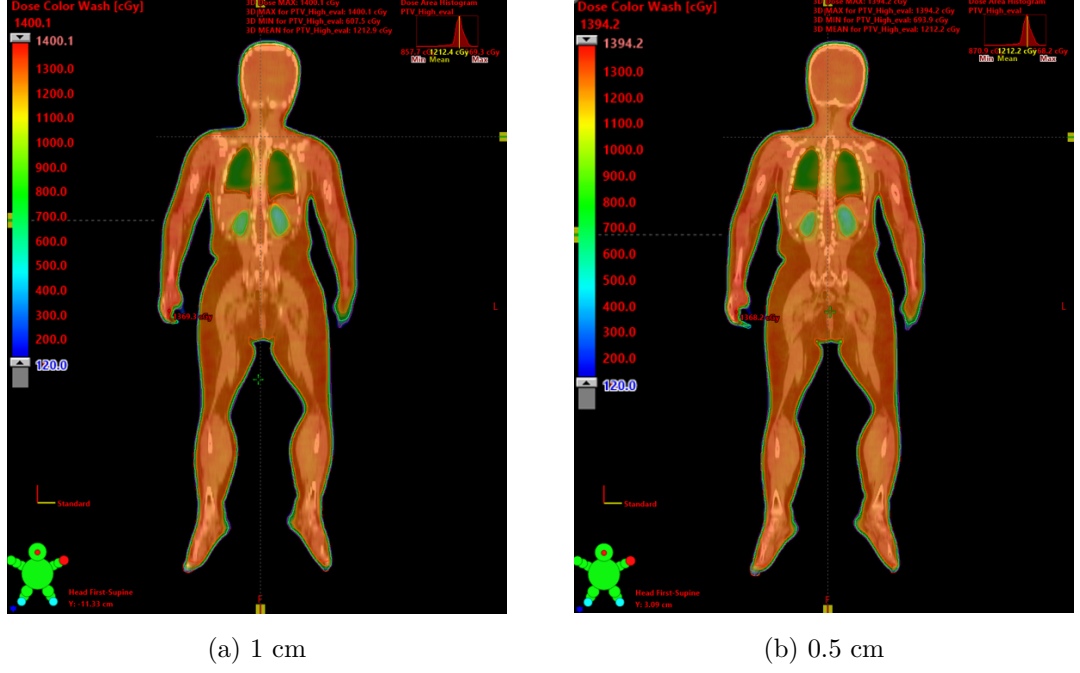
Achieved dose distribution with 1 and 0.5 cm of CT slice thickness (Patient #7).
